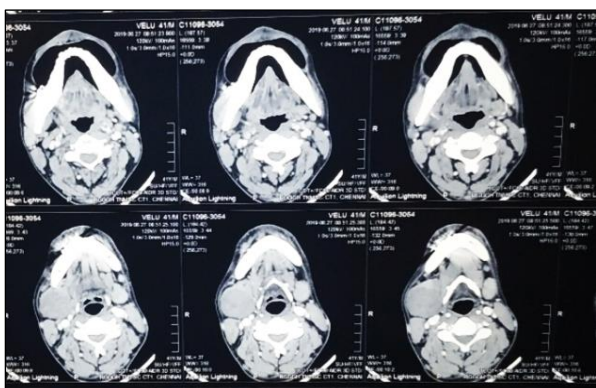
CT picture of case report 1.
